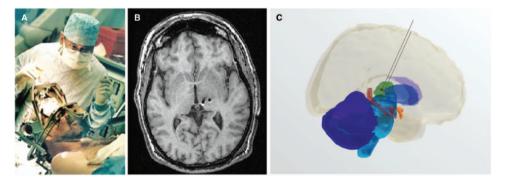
Deep brain stimulation. (A) Professor Tipu Aziz inserting a deep brain stimulator into a patient. (B) an MRI scan after surgery showing the position of the stimulator electrodes (the two small black circles near the centre of the image) in the left thalamus and perventricular grey. (C) A 3D reconstruction of the brain indicating the position of the stimulator electrodes (the two thin straight lines).
